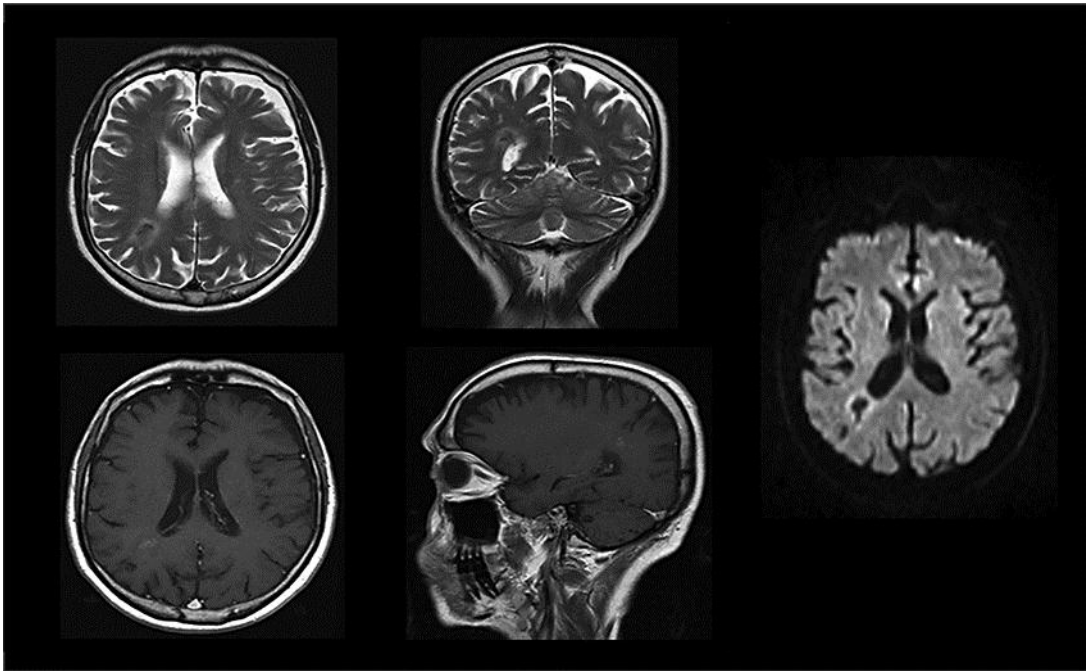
MRI of the brain evidencing almost complete resolution of the cerebral abscess after 12 weeks of treatment with trimethoprim-sulfamethoxazole.
